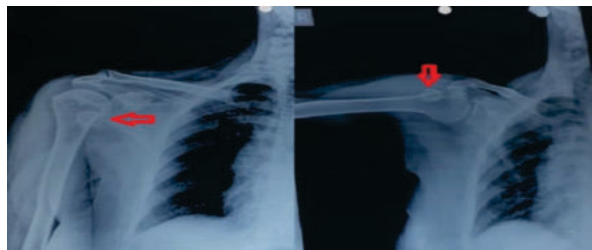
Preoperative radiographs of the shoulder joint.
